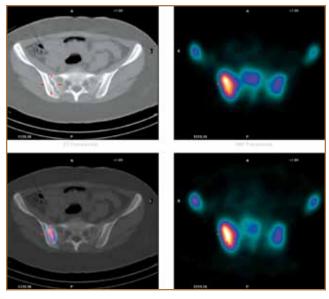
SPECT/CT demonstrating a widened right sacroiliac joint with increased inflammatory activity.
